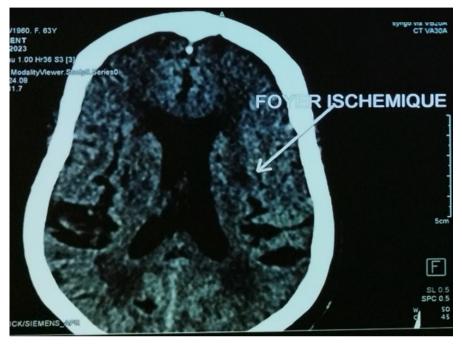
Cerebral CT scan showing ischaemic strok.
